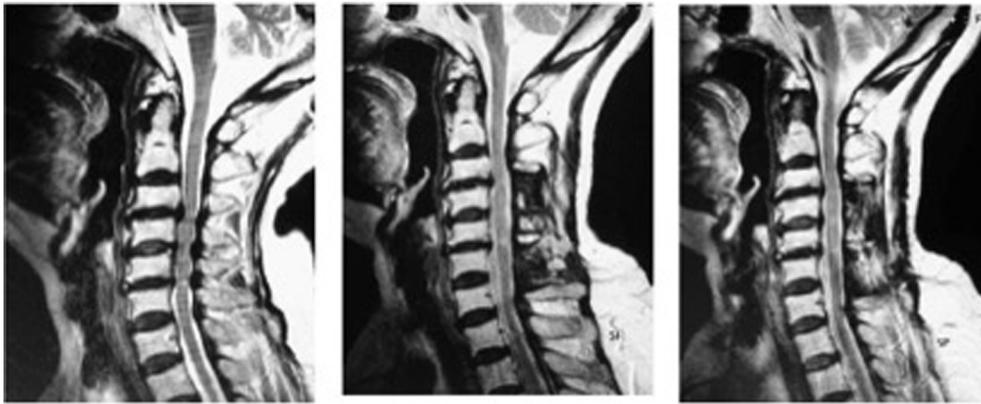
Sagittal MRI demonstrating pre-operative multilevel cervical spinal cord compression and post-operative appearances following C4 and C6 skip laminectomy at 6 weeks and 2 years. Taken from Shiraiishi [9].
